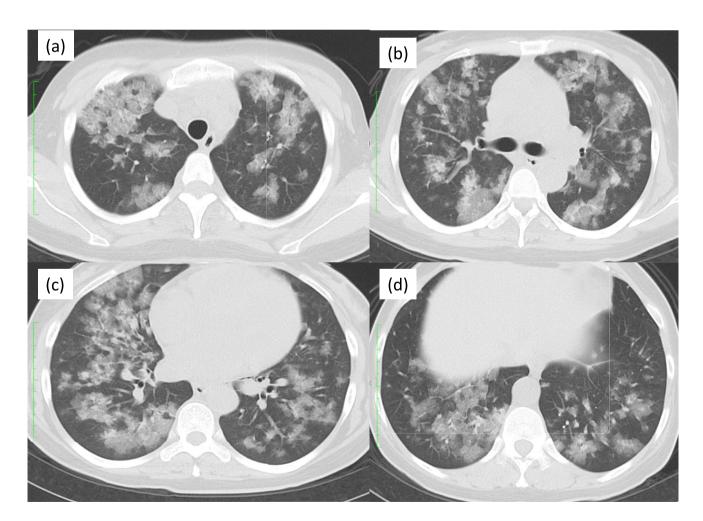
Computed tomography findings. Extensive mottled shadows were observed throughout both lung fields. a Lung fields of the upper lobe; b lung fields of the upper middle lobe; c lung fields of the lower middle lobe; d lung fields of the lower lobe
